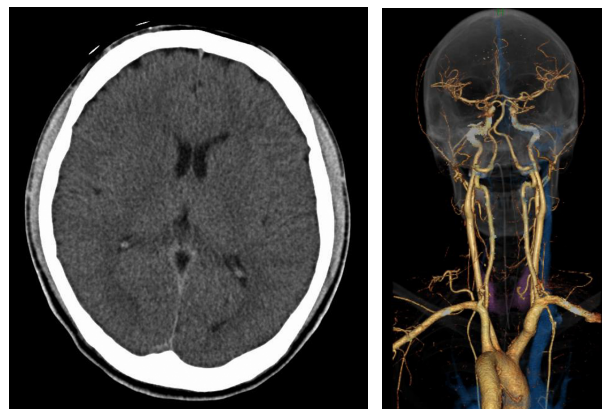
Initial brain CT scan after resuscitation demonstrates an unclear border between the gray matter and the white matter; however, blood supply to the brain was normal.
